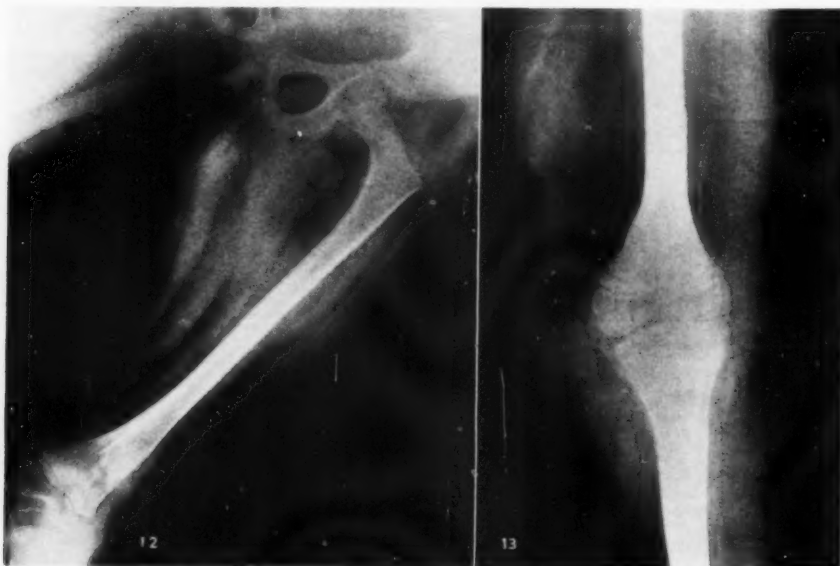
Anteroposterior roentgenogram of the left thigh area in Case 12, demonstrating characteristic muscle bundle atrophy and osteoporosis. Note the stigma of a flexion contracture of the left knee.
